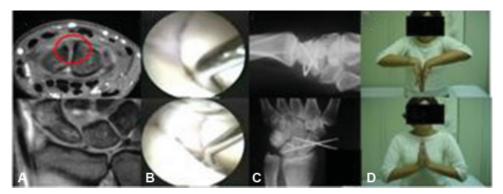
Incomplete scapholunate ligament lesion (SLIL). (A) Nuclear magnetic resonance imaging shows the lesion at the dorsal region of SLIL; (B) Geissler type III lesion classified by probe-scope rotation at the radial midcarpal portal (MCR) and probe at the midcarpal ulnar portal (MCU); (C) carpus fixation for 6 weeks; (D) functional outcome.
